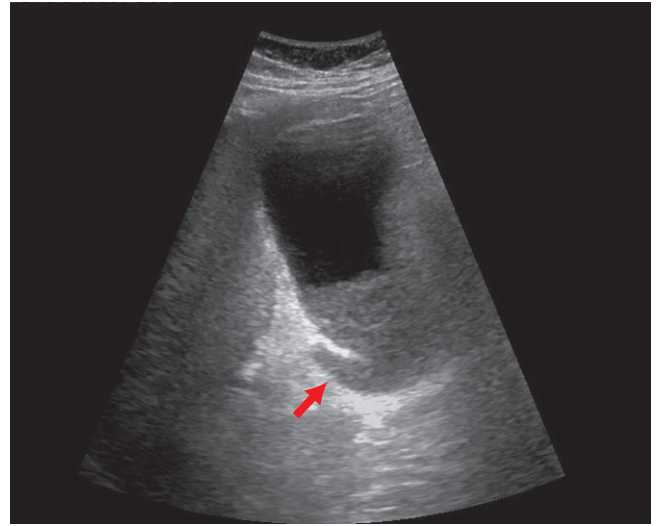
The sonographic image of the distended gallbladder shows the neck (arrow) filled with sludge. There are no gallstones.
